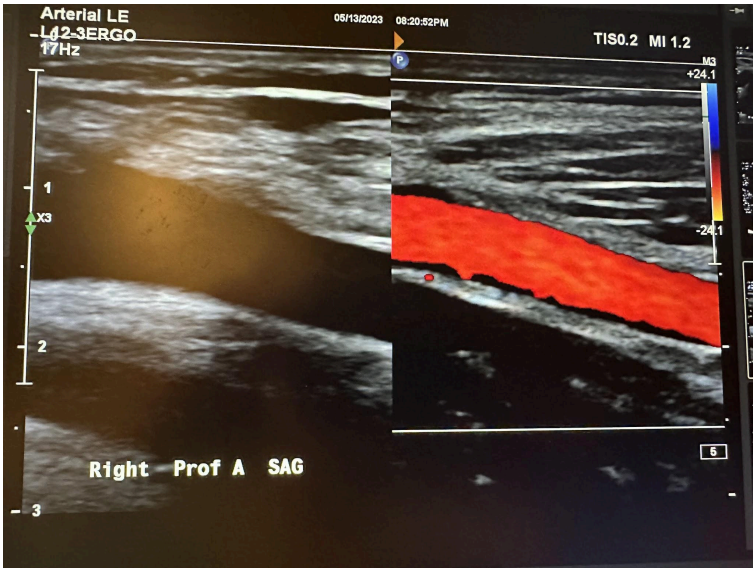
Side-by-side sagittal images of the right profunda femoral artery without color Doppler and with color Doppler.
